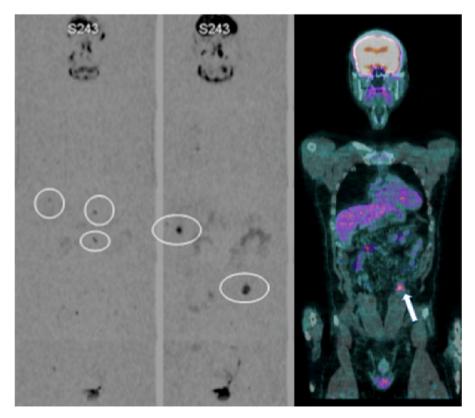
38 years old man. Examples of multiple subcutaneous and intra-peritoneal nodes well visualized on a coronal reconstruction of the DW sequence (images on the left and on the middle, white circles) with a size inferior to 7 mm. Only one node was detectable on the images provided by PET-CT examination (image on the right, white arrow).
